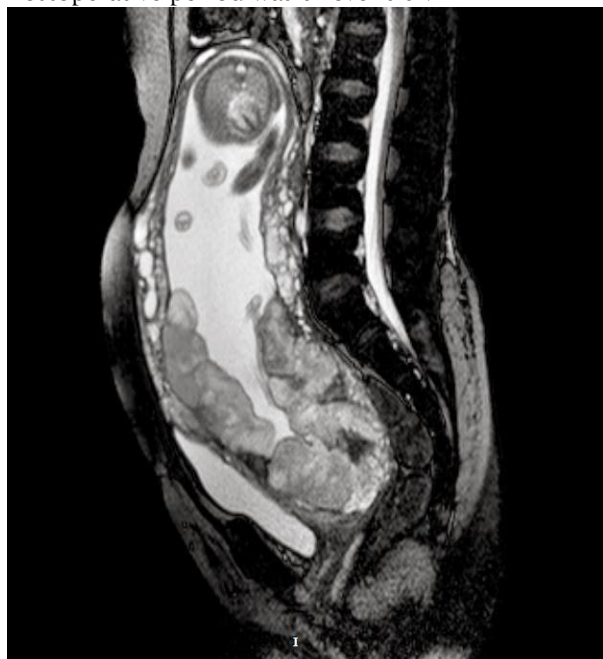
T2-weighted MRI showing placental tissue invading into the myometrium without extending to the serosal surface.
